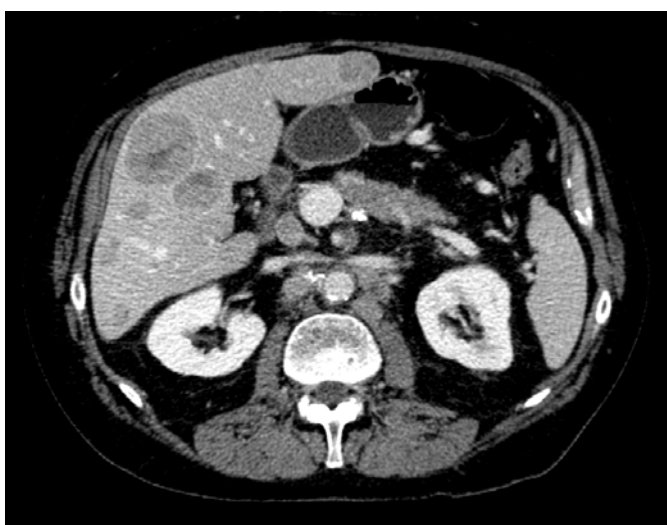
Transverse i.v. contrast-enhanced CT in the venous phase showing hypovascular (dark) liver metastases.
